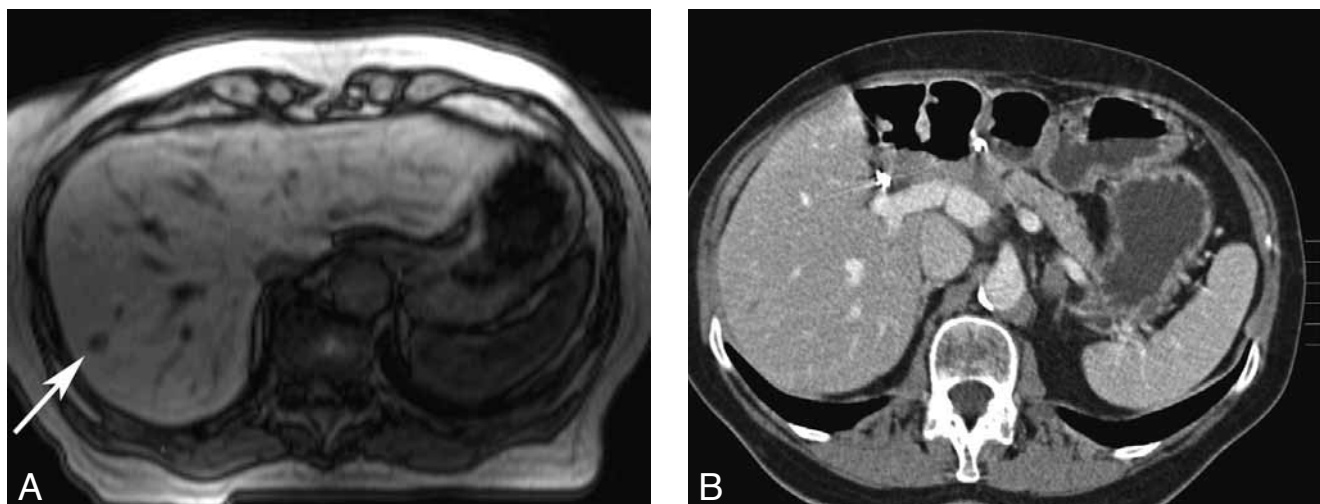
Mangafodipir-enhanced MRI is superior to contrast-enhanced MDCT for lesion detection. A. The mangafodipir-enhanced T1w GRE images shows a small lesion in the right lobe (arrow). B. The lesion is only faintly seen at MDCT.
